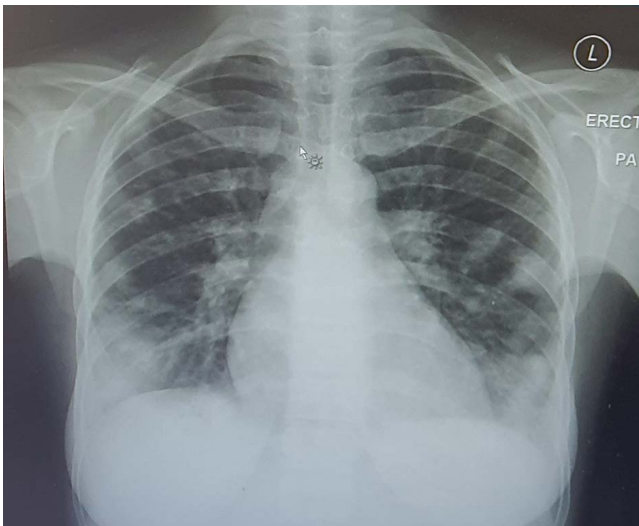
Chest X-ray depicting multiple variable-sized pulmonary metastatic nodules bilaterally
